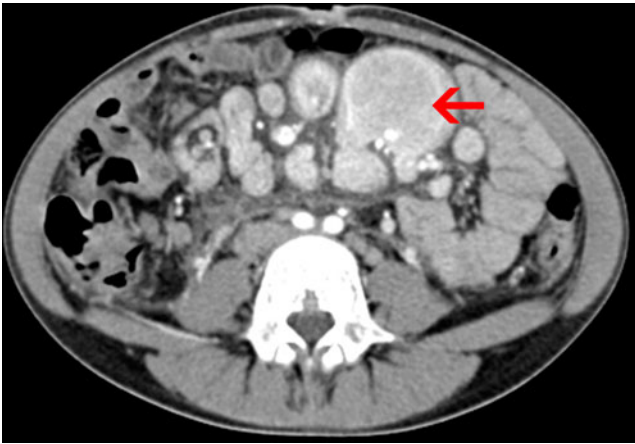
CT showing a mass with moderate contrast enhancement in abdomen (*arrow*)
